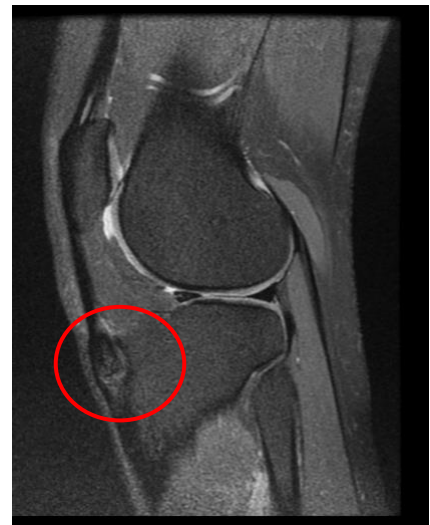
Sagittal MRI image showing edema at the ossicle and the synchondrosis.¹⁵
